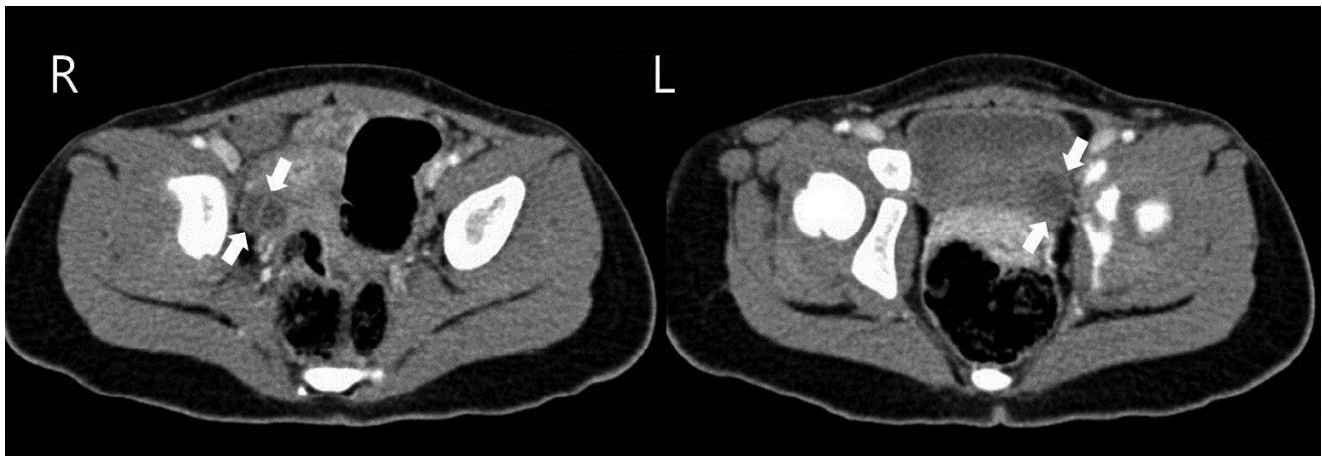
Computed tomography of pelvis
